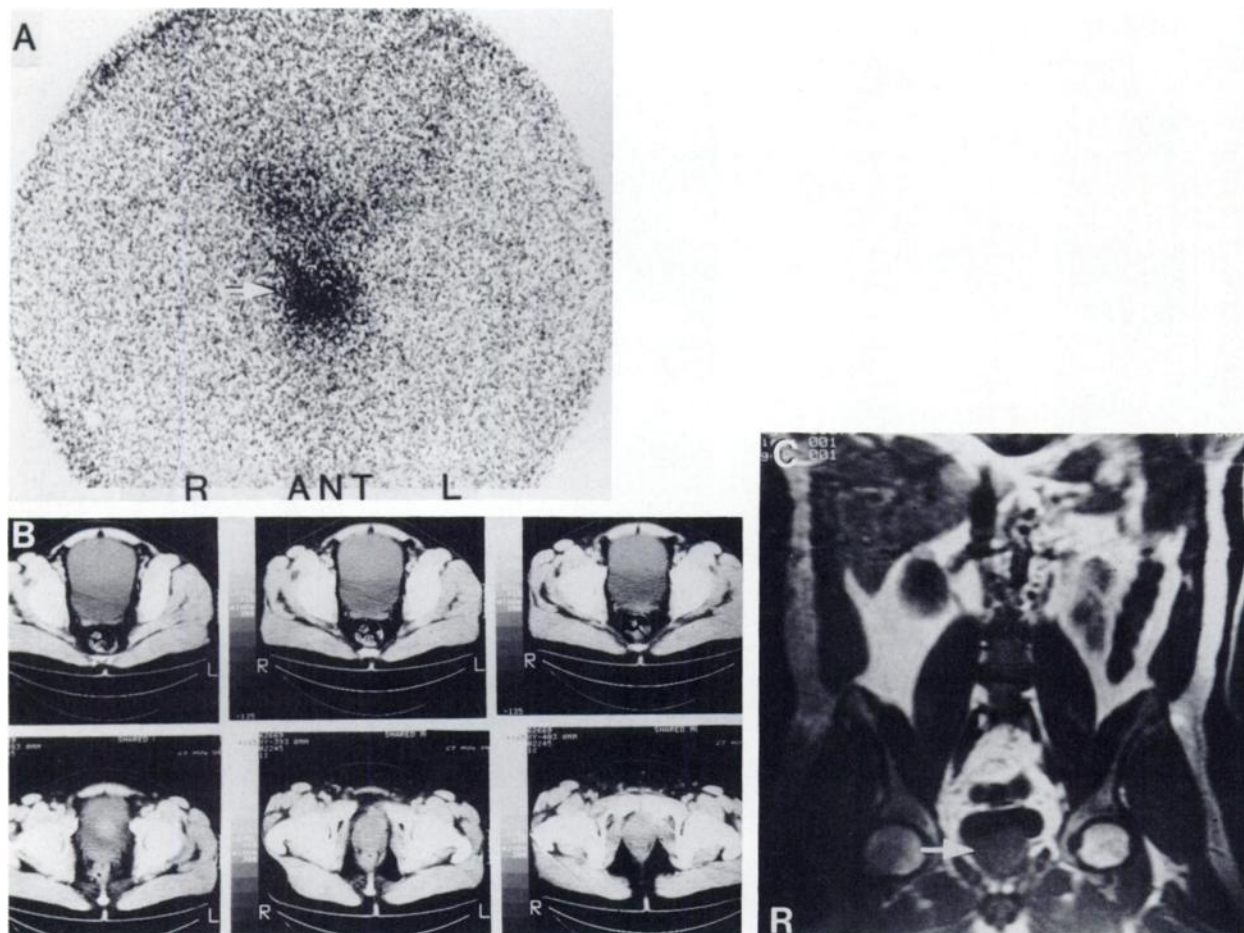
Perivesical pheochromocytoma; FN CT and MRI (Patient 12). A: MIBG. An anterior image (50k) of the pelvis obtained 48 hr after the i.v. administration of 0.5 mCi of [¹³¹I]MIBG shows an intense abnormal focus of radioactivity in the perivesical region (arrowhead). Above this, faint activity is seen in the bladder. B: CT. Multiple transverse slices through the pelvis are unremarkable. C: MRI. A T₁ weighted (TR=600 msec; TE=20 msec) coronal image shows a mass of intermediate signal in intensity in the region of the prostate (arrowhead) that was initially interpreted to be prostatic hypertrophy but corresponds to the abnormality seen by scintigraphy. Pathology. Perivesical pheochromocytoma.
